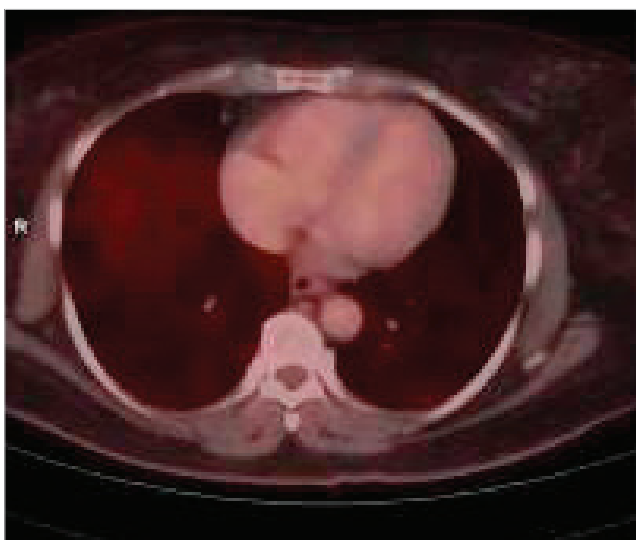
(Case 2) Baseline PET CT : Transaxial view of lung showing no metabolically active lesions.
